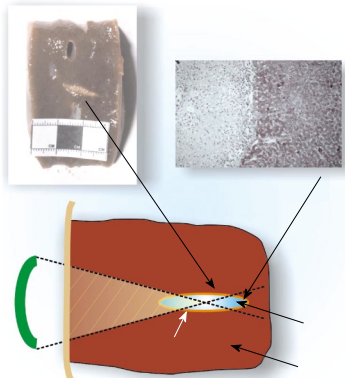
The high intensity focused ultrasound beam passes through overlying skin and other tissues without harming them and is focused to necrose a localized tumor region, which may lie deep within the body. There is a very sharp boundary between dead and live cells at this contour.
